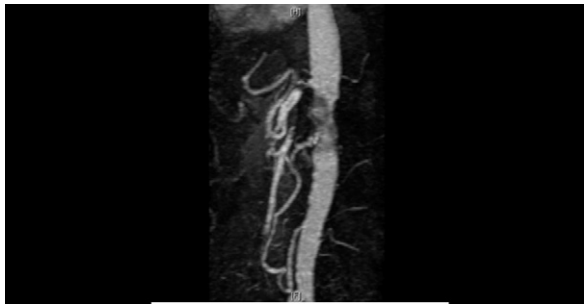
Magnetic resonance imaging shows the infrarenal aortic angiosarcoma has occluded the celiac, superior mesenteric, and right renal arteries. The inferior mesenteric artery is patent.
